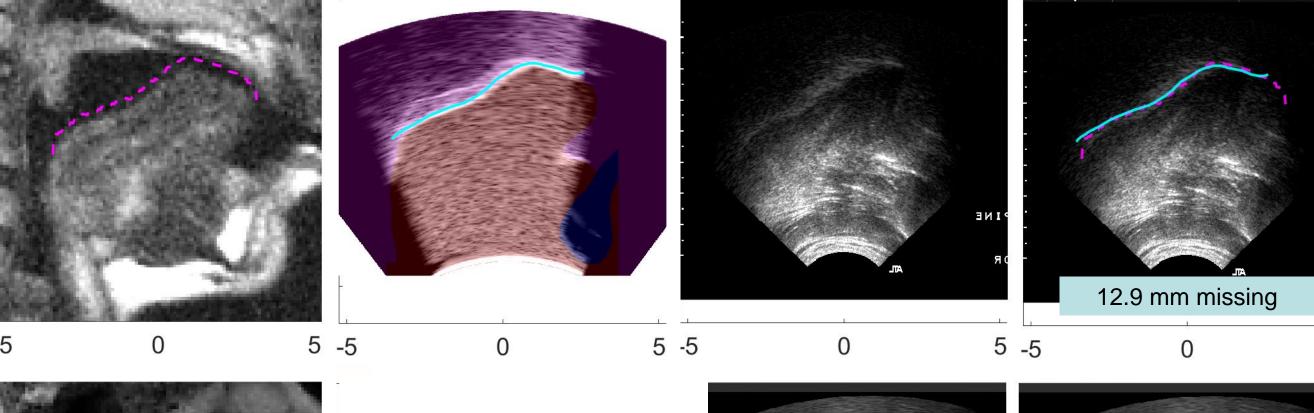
Midsagittal MRI of speakers with columns indicating the manually
